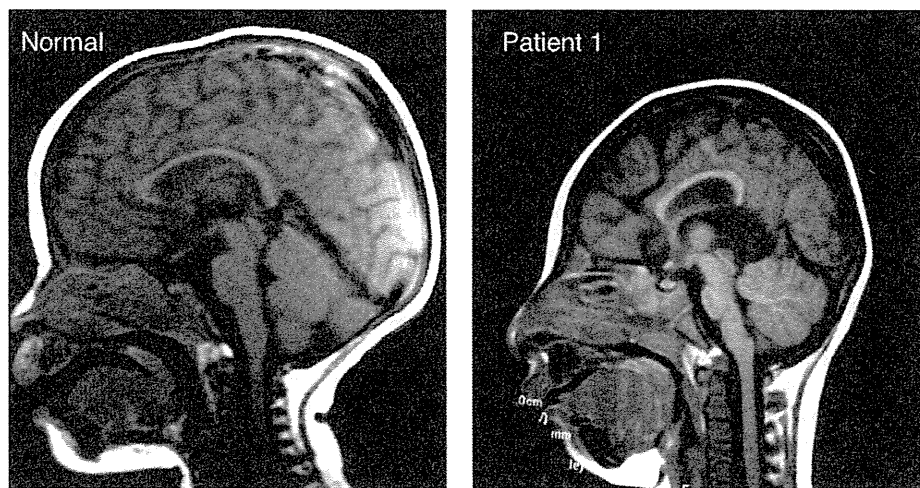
Sagittal brain magnetic resonance imaging. (Left) Normal individual. (Right) Patient 1 at age 18 months with generalized cerebral hypodysplasia.
